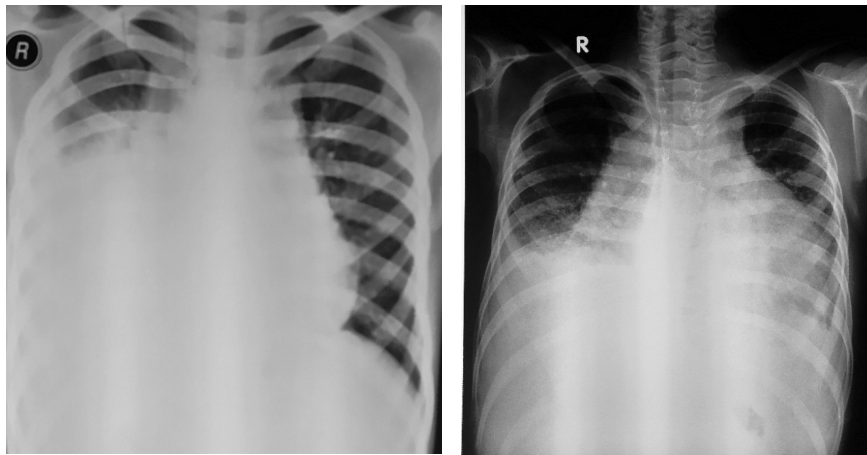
Chest X-rays of Case 1. Left: 2 months before admission to our hospital. Right: chest X-ray performed in our hospital.
